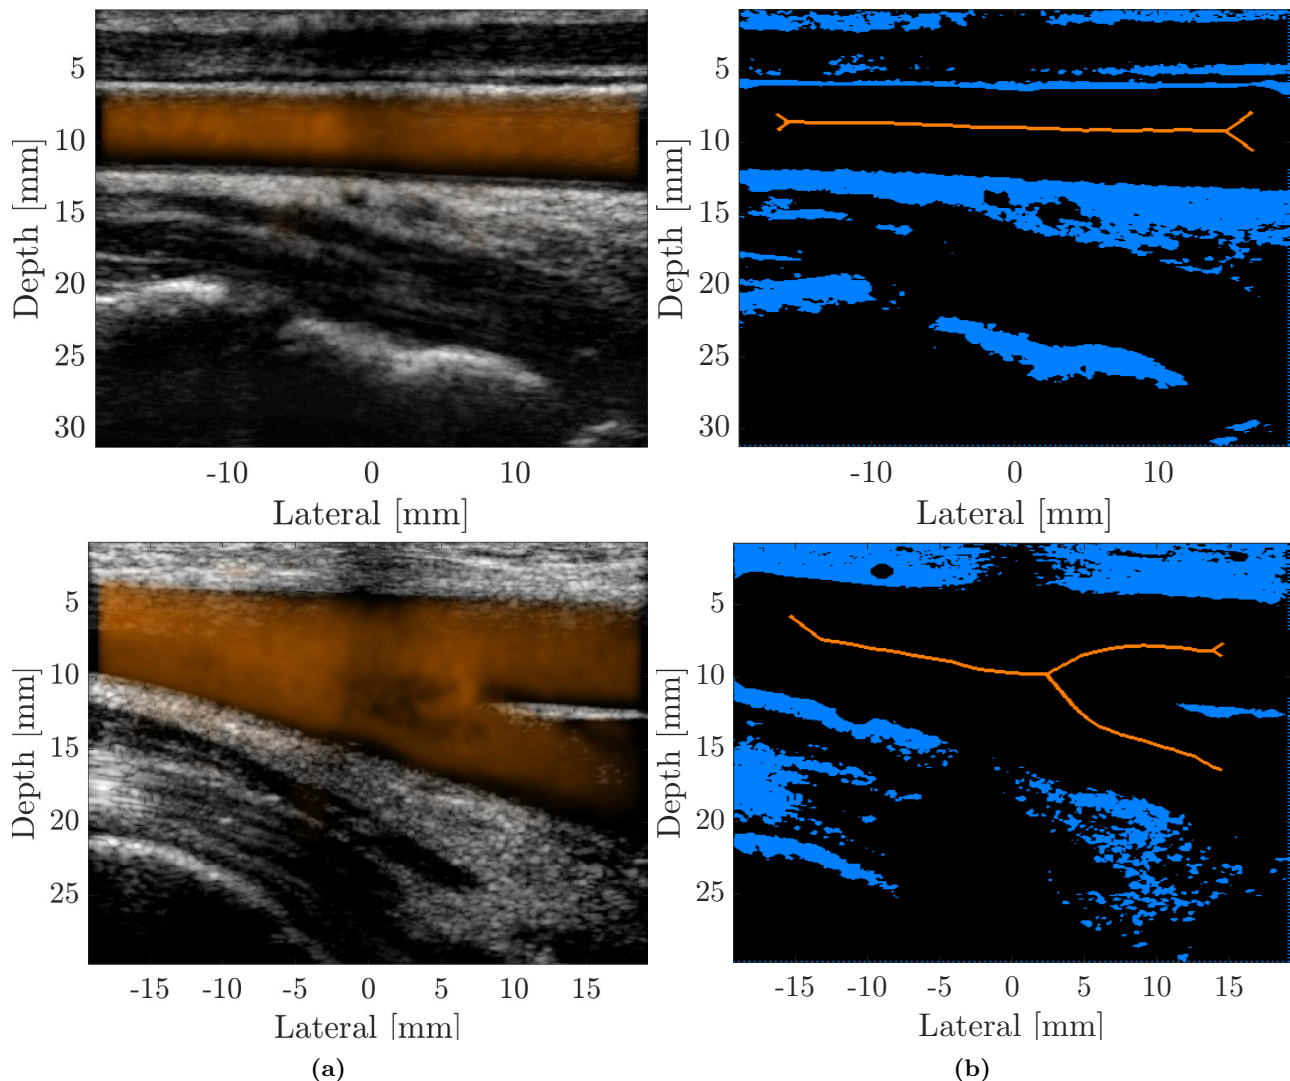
Examples of marker images. Top: CCA. Bottom: FAB. (a) Average of 81 power Doppler images superimposed on the B-mode images. (b) Marker images. Orange and blue colors represent the inner and outer markers, respectively.
